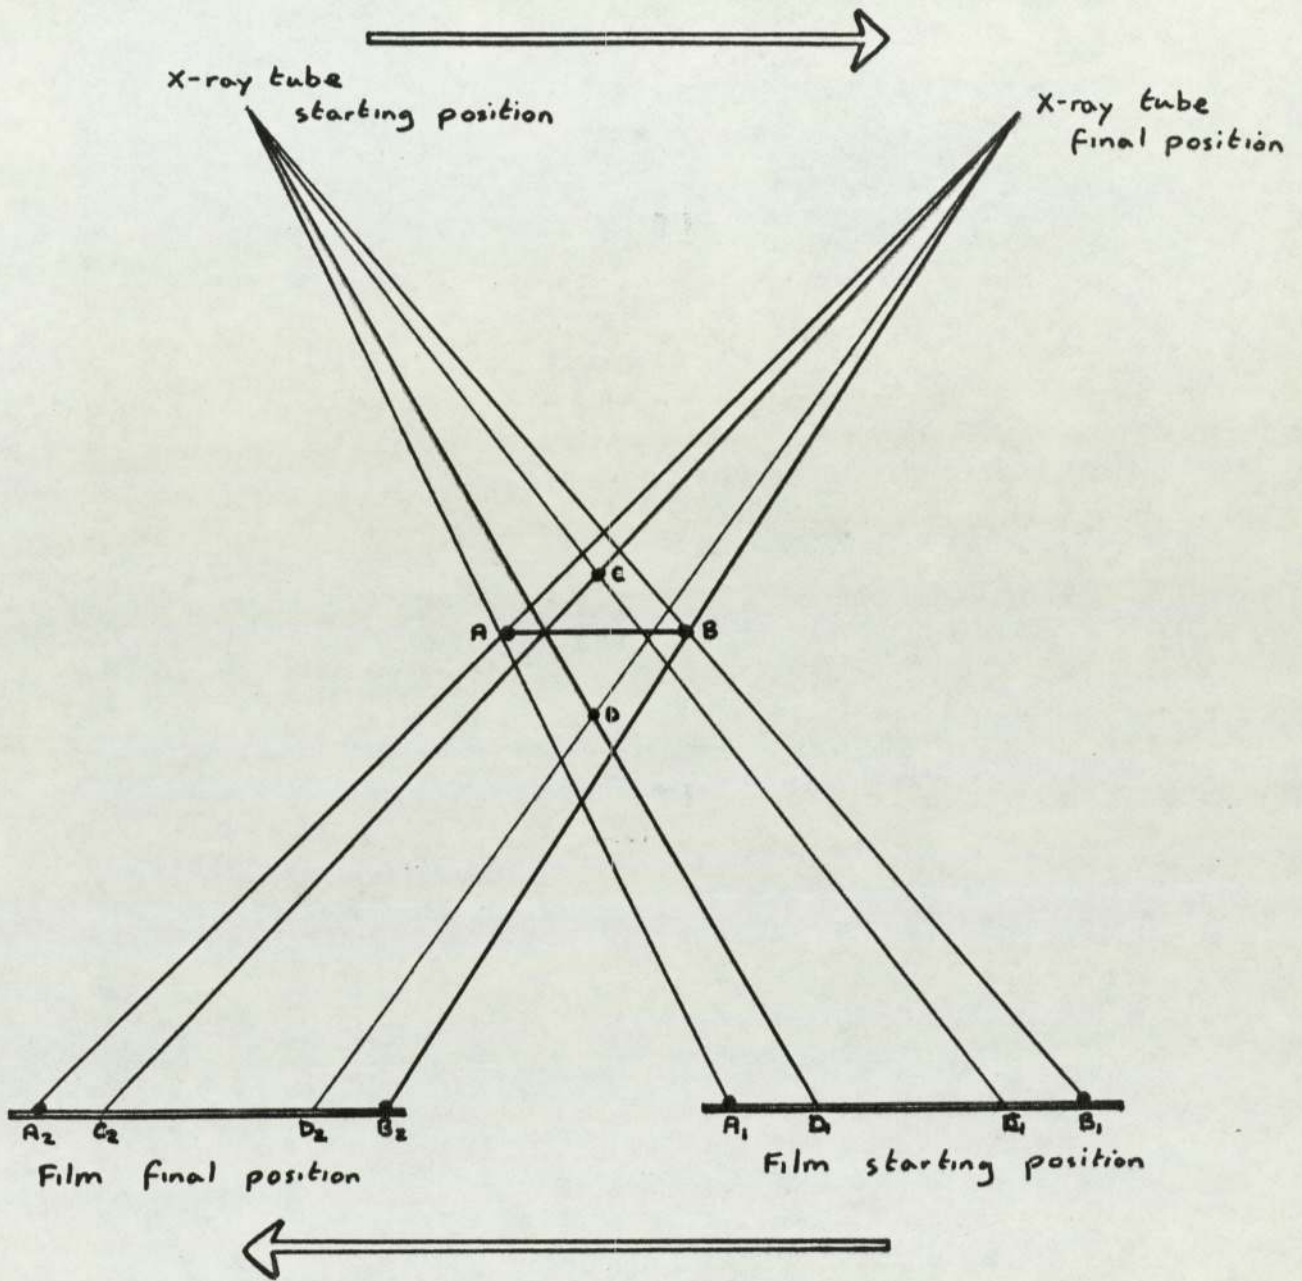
The mechanism of conventional X-ray tomography
